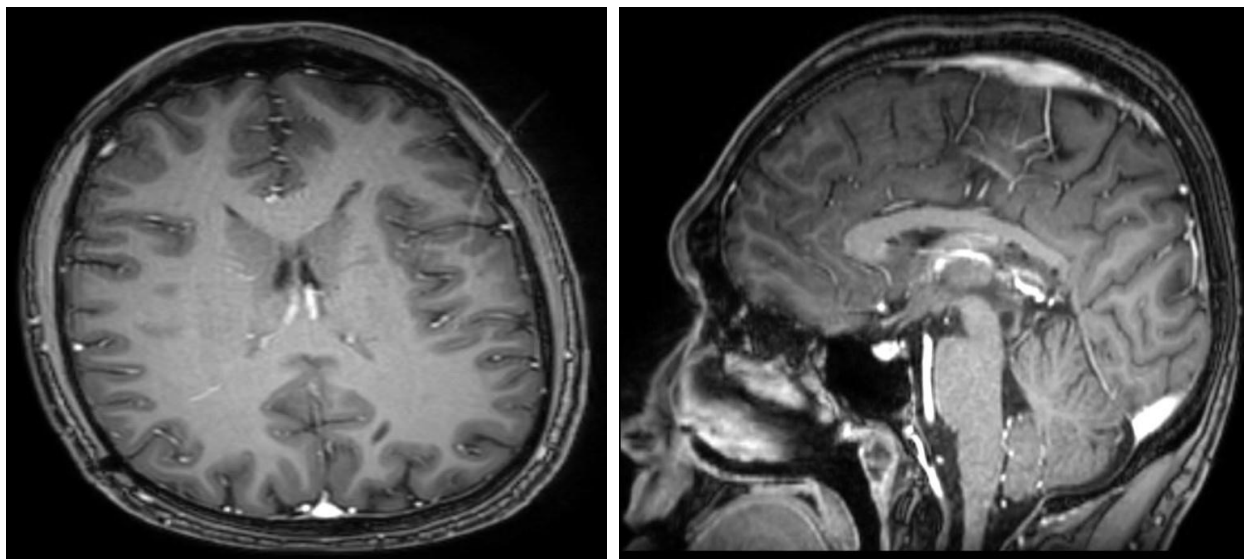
Post-radiotherapy control MRI (Sagittal and Axial section) at 2 years showing a visible tumor absence of the pineal region and absence of dilation of the ventricular system.
